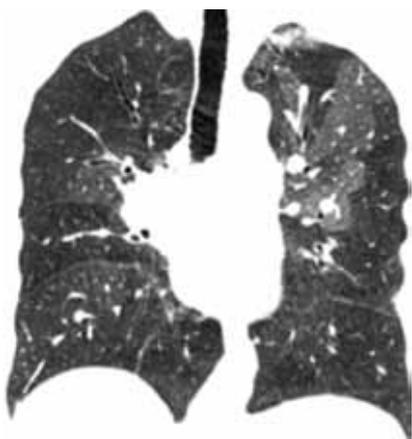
Coronal CT, lung window reconstruction in a 65 year old male with CTEPH. The black areas represent abnormal perfusion with reduced vessel count whilst the grey zones represent preserved perfusion.
